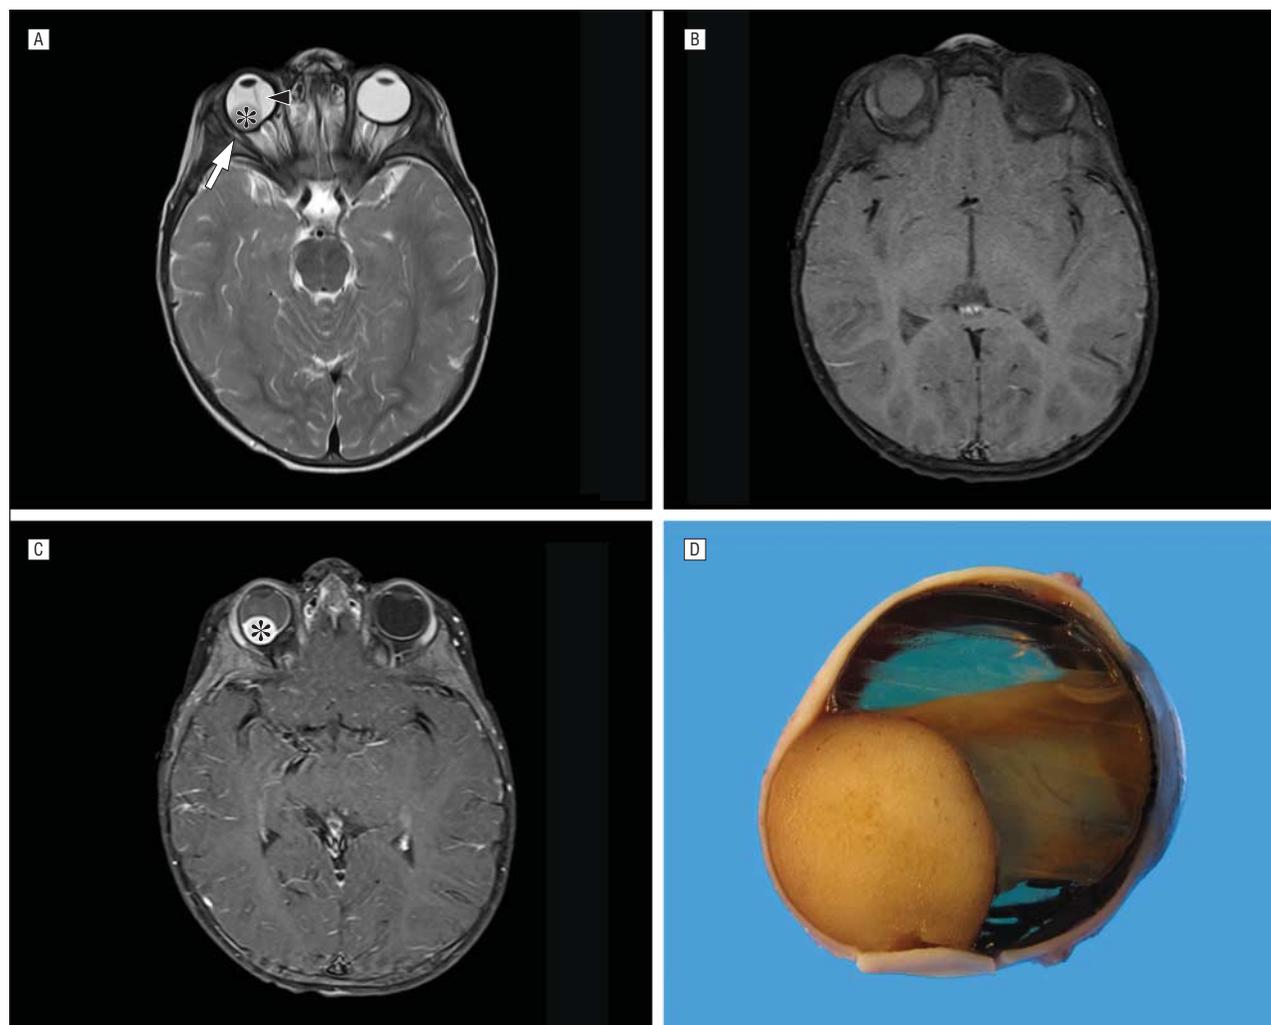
Magnetic resonance images and clinical photograph. Axial non-fat-saturation T2-weighted (A), contrast-enhanced T1-weighted (B), and axial fat-saturation T1-weighted (C) magnetic resonance images show a uniformly enhancing right intraocular mass (asterisks in A and C). Note the deformation of the sclera adjacent to the mass (arrow in A), with no evidence of scleral, extrascleral, or optic nerve extension. The right globe is smaller than the left. The retinal detachment is well seen (arrowhead) on the T2-weighted image (A). D, The enucleated globe shows a solid cream-colored tumor in the posterior choroid. Note the complete retinal detachment and gelatinous subretinal fluid.
